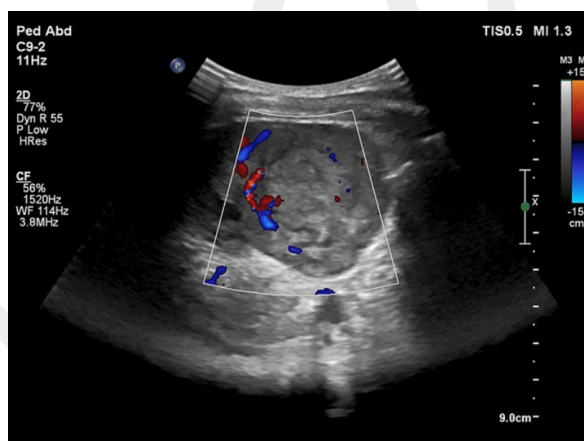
Doppler ultrasonography demonstrating vascular flow within the splenic lesion
